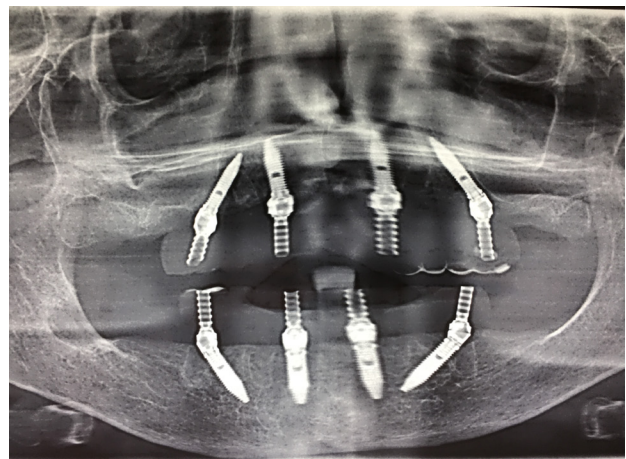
Post-surgery and immediate loading Orthopantomography.*
